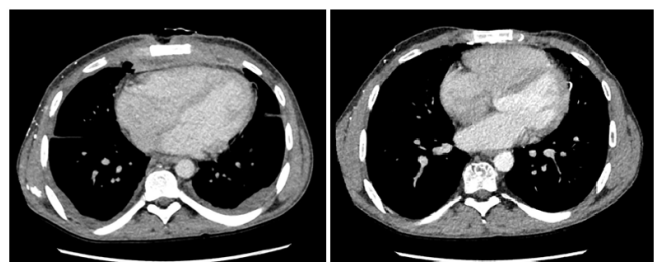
Cross sectional CT imaging chest. (L) revealing soft tissue thickening and retrosternal collection along the lower half of the body of the sternum despite 10 months treatment (August 2018). (R) revealing complete resolution of soft tissue thickening and retrosternal collection following bacteriophage therapy (August 2019).
